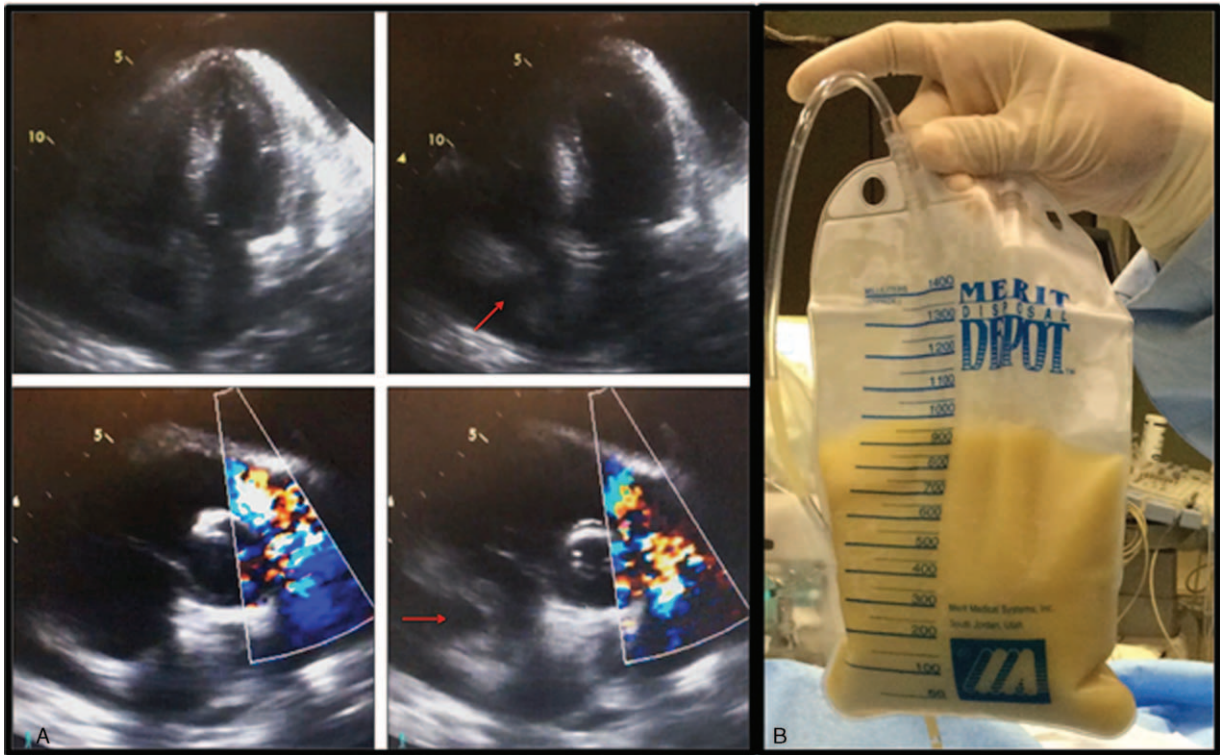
Transthoracic echocardiography and pericardial fluid. (A) Motion frames in an apical four-chamber view (top) and parasternal short axis view (bottom) of a transthoracic echocardiogram revealing circumferential pericardial effusion with right atrial diastolic wall collapse (red arrows) suggestive of cardiac tamponade. (B) Purulent appearing pericardial fluid.
